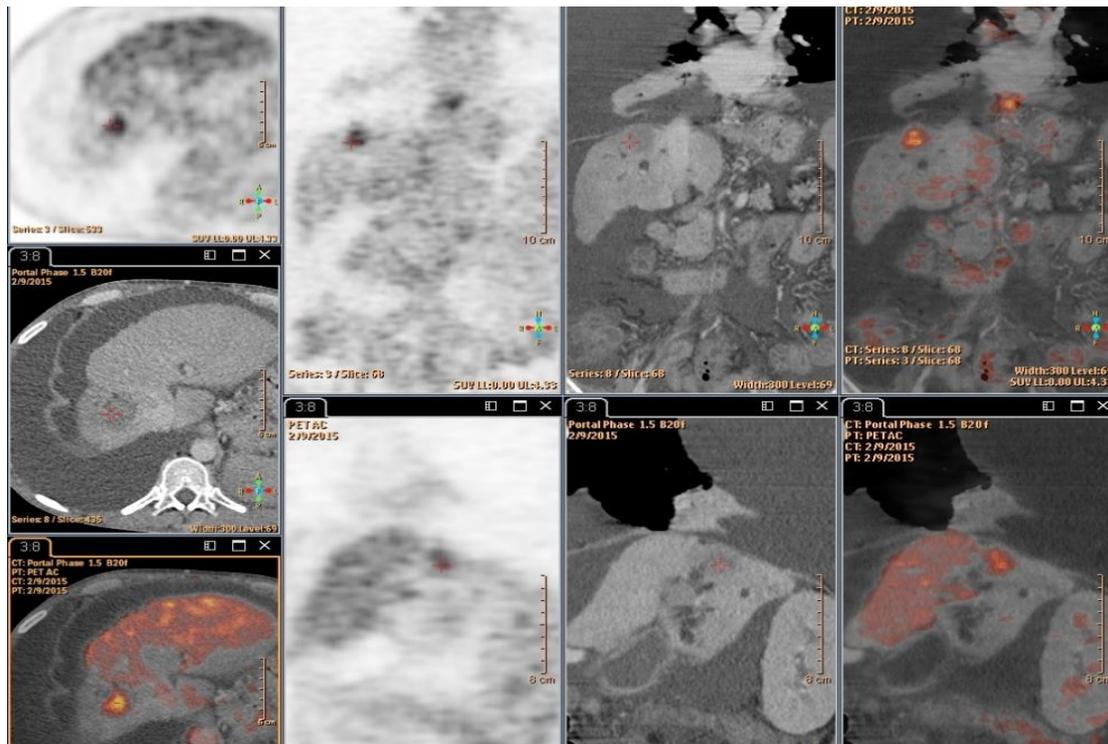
49-year-old male patient with liver cirrhosis with multiple focal lesions in segments V / VII / VIII with SUVmax 3.8 – 4.4 with hypoenhancement in triphasic CT.
